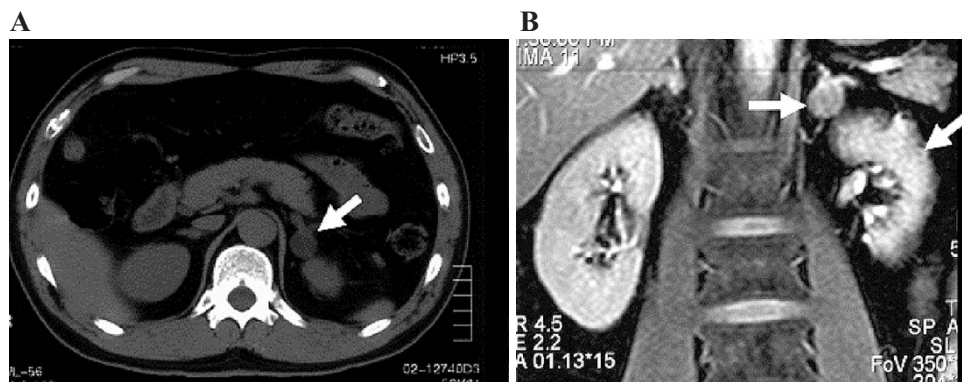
Abdominal MRI transvers section (A) and coronary section (B) show a left adrenal tumor (18 mm) and small left kidney (87 mm).
